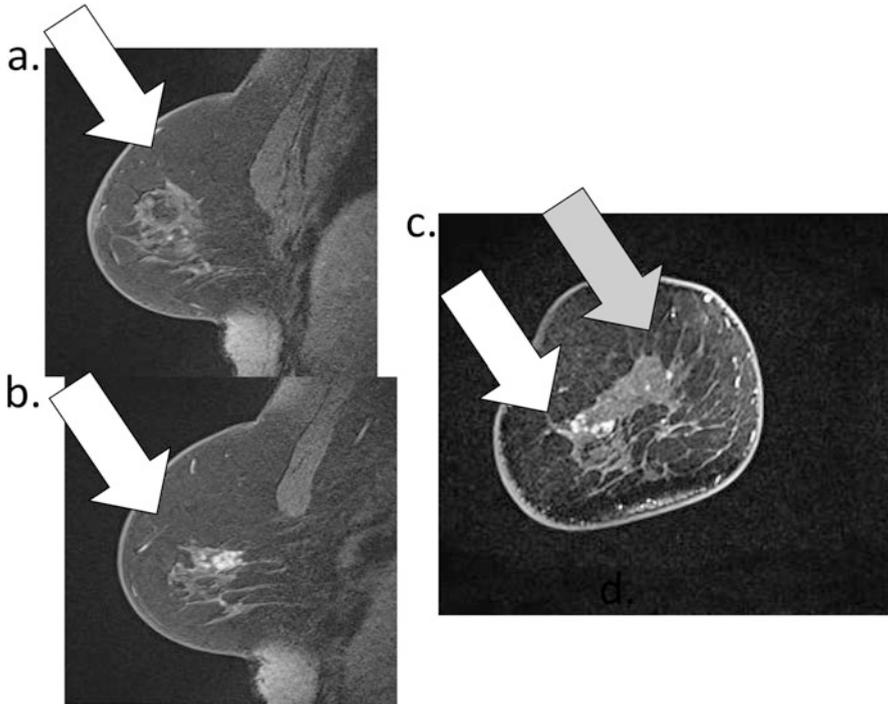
IBTR after nonsurgical cryoablation with breast MRI. (a) Ablated area (*white arrow*) on sagittal section. (b) IBTR (*white arrow*) in right outer region on sagittal section. (c) IBTR (*grey and white arrow*) was caudal to ablated area on coronal section
